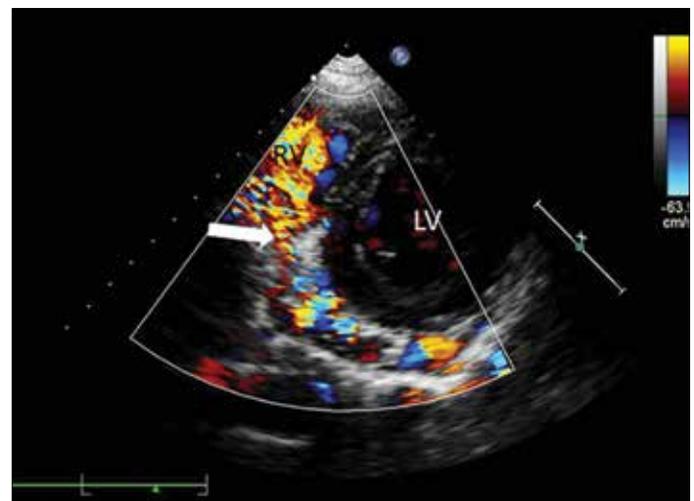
In the parasternal short-axis view at ventricular level Doppler echocardiography shows abnormal mosaic vascular structure flowing via the left atrioventricular groove toward inflow of right ventricle (RV) near tricuspid valve (white arrow)
